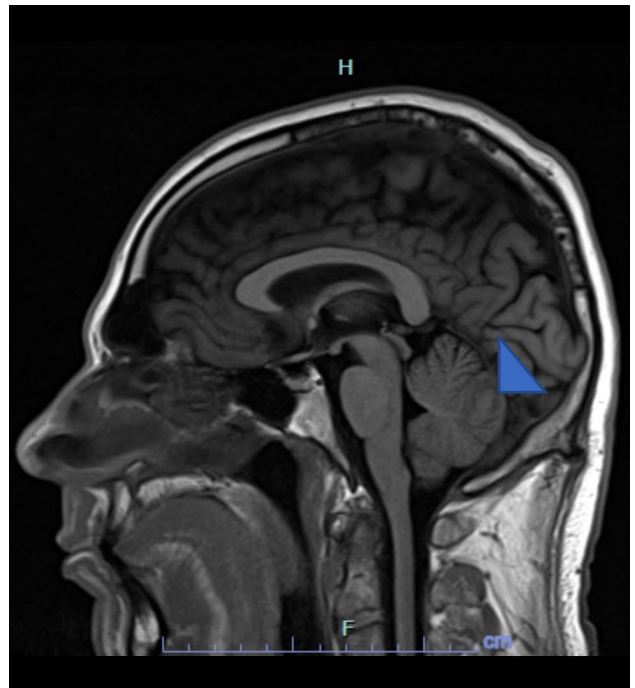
T1-weighted FLAIR magnetic resonance imaging demonstrating a minimal local mass effect on the adjacent brain parenchyma with subtle effacement of the sulci.
